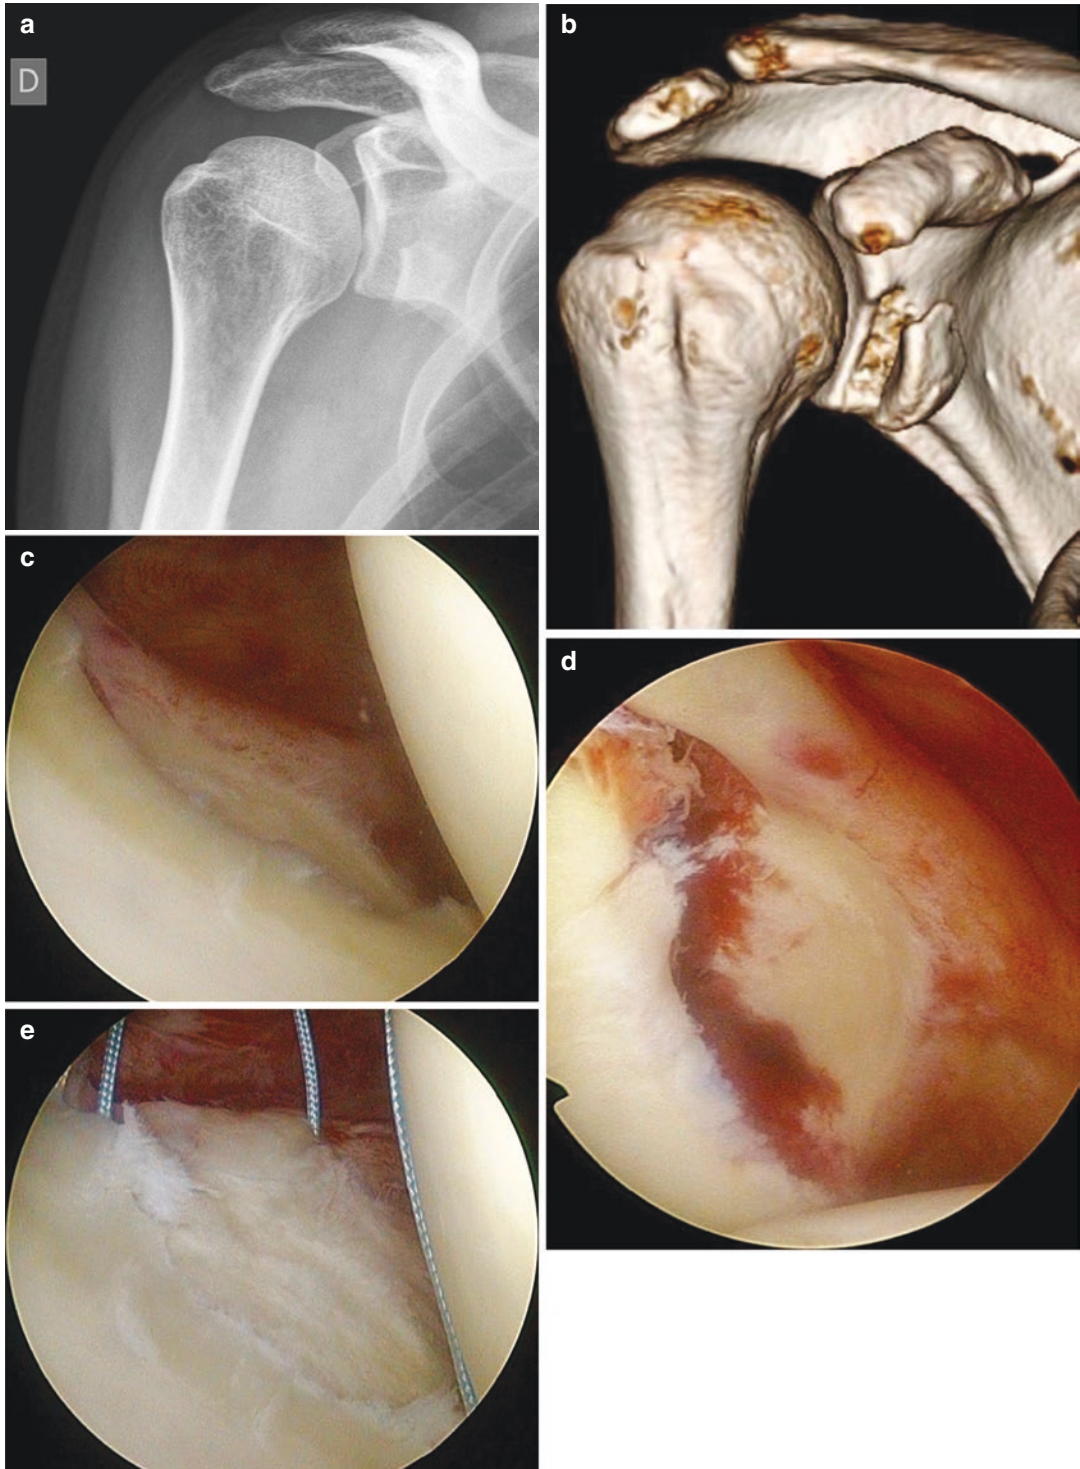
Clinical case of arthroscopic treatment of anterior glenoid rim fracture. Initial radiograph (a) and CT scan (b). Arthroscopic view of the same fracture from posterior portal (c) and anterior portal (d). Reduction of the fracture and sutures in place through labro-ligamentous
